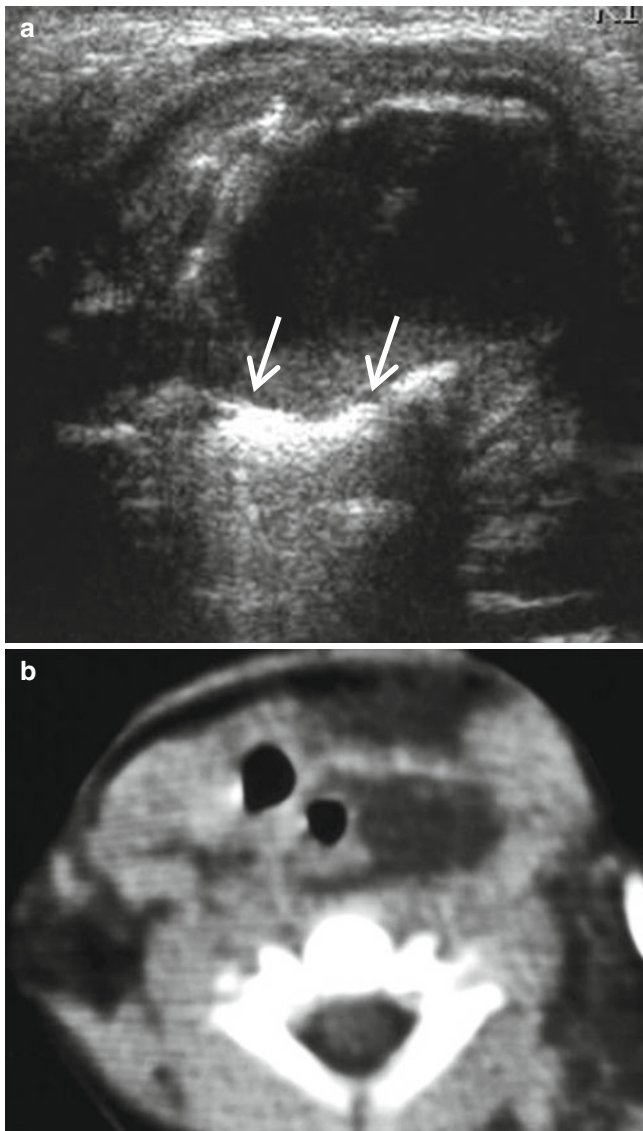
Enteric duplication cyst in a 1-month-old infant. (a) US shows a thick-walled cyst in the left lateral aspect of the esophageal gas (*arrows*). (b) Axial CT scan shows a unilocular cyst abutting the left lateral wall of the esophagus
